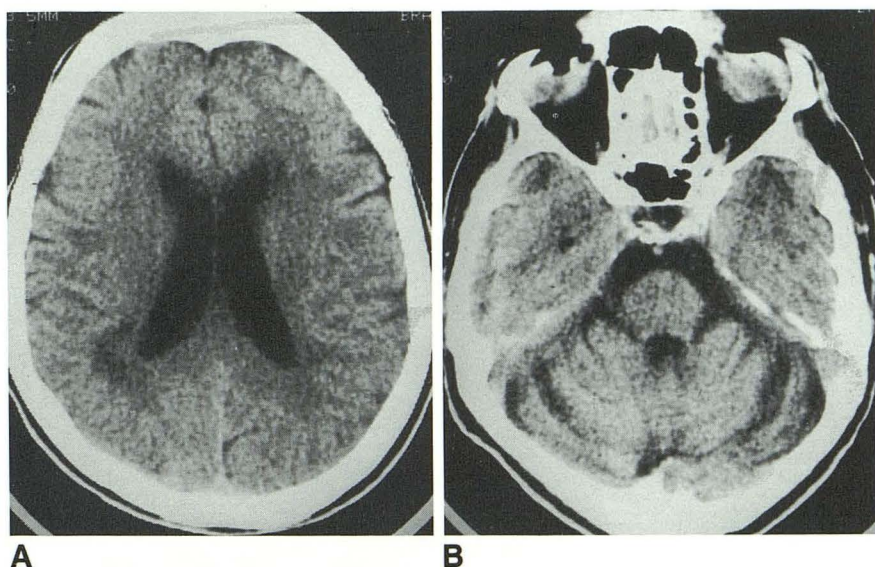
MERRF; 50-year-old woman with progressive proximal weakness, myoclonus, and mild dementia. *A* and *B*, Axial CT; there is mild cerebral atrophy, marked cerebellar atrophy, and ill-defined low-density lesions in the cerebral white matter.
